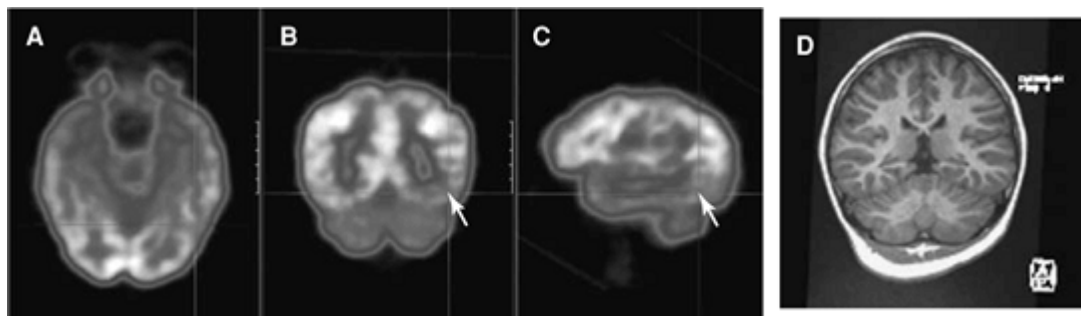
An area of decreased glucose uptake in the floor of the left temporal lobe (*arrows*) in a patient with photosensitive epilepsy and complex partial seizures (A–C). In this case the magnetic resonance imaging was normal (D). (Image courtesy of Sam Berlangieri, Austin Health, Melbourne, Australia.)
